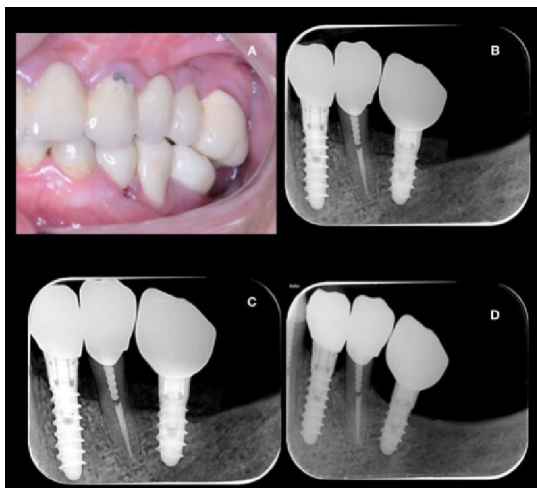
A: lateral view to the final prosthesis B: periapical xray for 6 month follow up C: periapical xray for 9 month D: periapical xray for 12 month.
